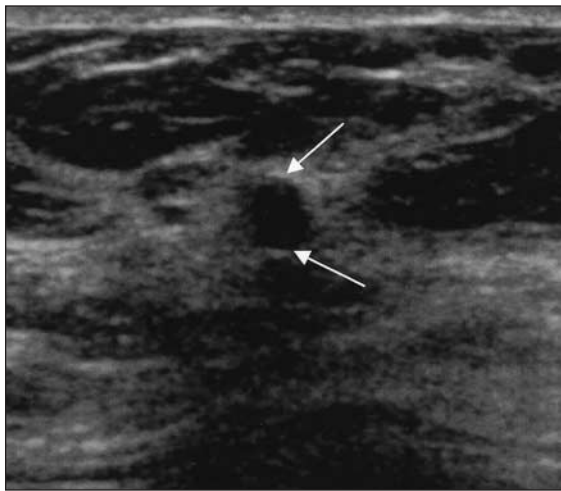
Sonogram from a 41-year-old woman who underwent screening sonography for a dense breast. The sonogram shows a 1-cm irregular, angular hypoechoic nodule. The anterior rim (arrow) is shown. The result of core needle biopsy was a galactocele.
